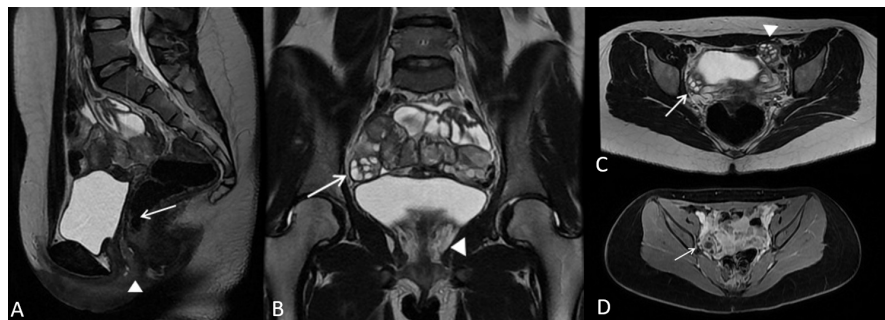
MRI findings. Sagittal T2-weighted sequence (A) demonstrating uterine (arrow) and proximal vaginal (arrowhead) agenesis. Coronal T2-weighted pre-contrast sequence (B) demonstrating the right ovary (arrow) and uterine agenesis (arrowhead). Axial T2-weighted pre-contrast sequence (C) demonstrating the right ovary (arrow) and left ovary (arrowhead) with follicles. Axial T1-weighted post-contrast sequence (D) demonstrating the right ovary with a follicle (arrow) and the absence of T1 hyperintense foci suggestive of hematometra.
